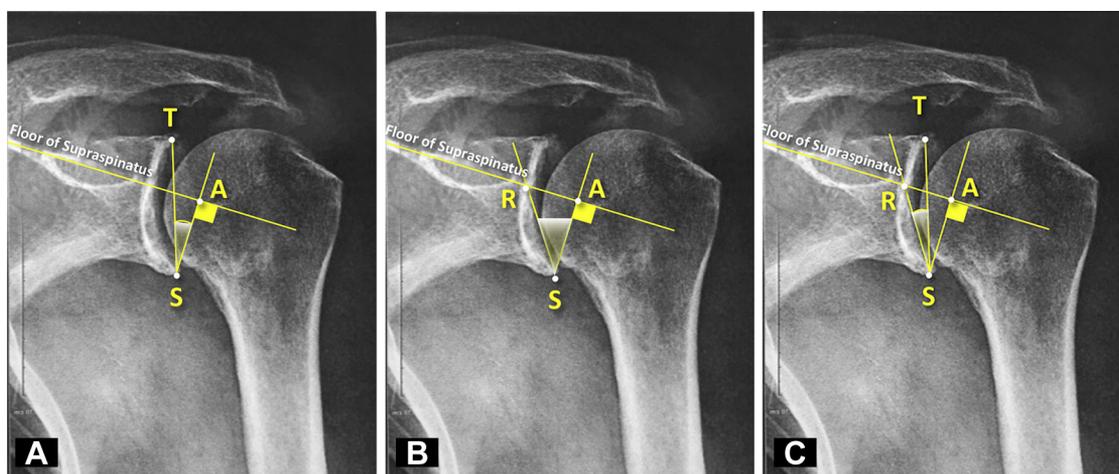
Measurements of total shoulder arthroplasty (TSA) angle (A) and reverse shoulder arthroplasty (RSA) angle (B) on plain anteroposterior radiographs. The RSA angle was defined as the angle between the inferior part of the glenoid fossa and the perpendicular to the floor of the supraspinatus fossa. The TSA angle is a variation of the β angle. The difference between the TSA and RSA angles is represented by the RST angle (C).
